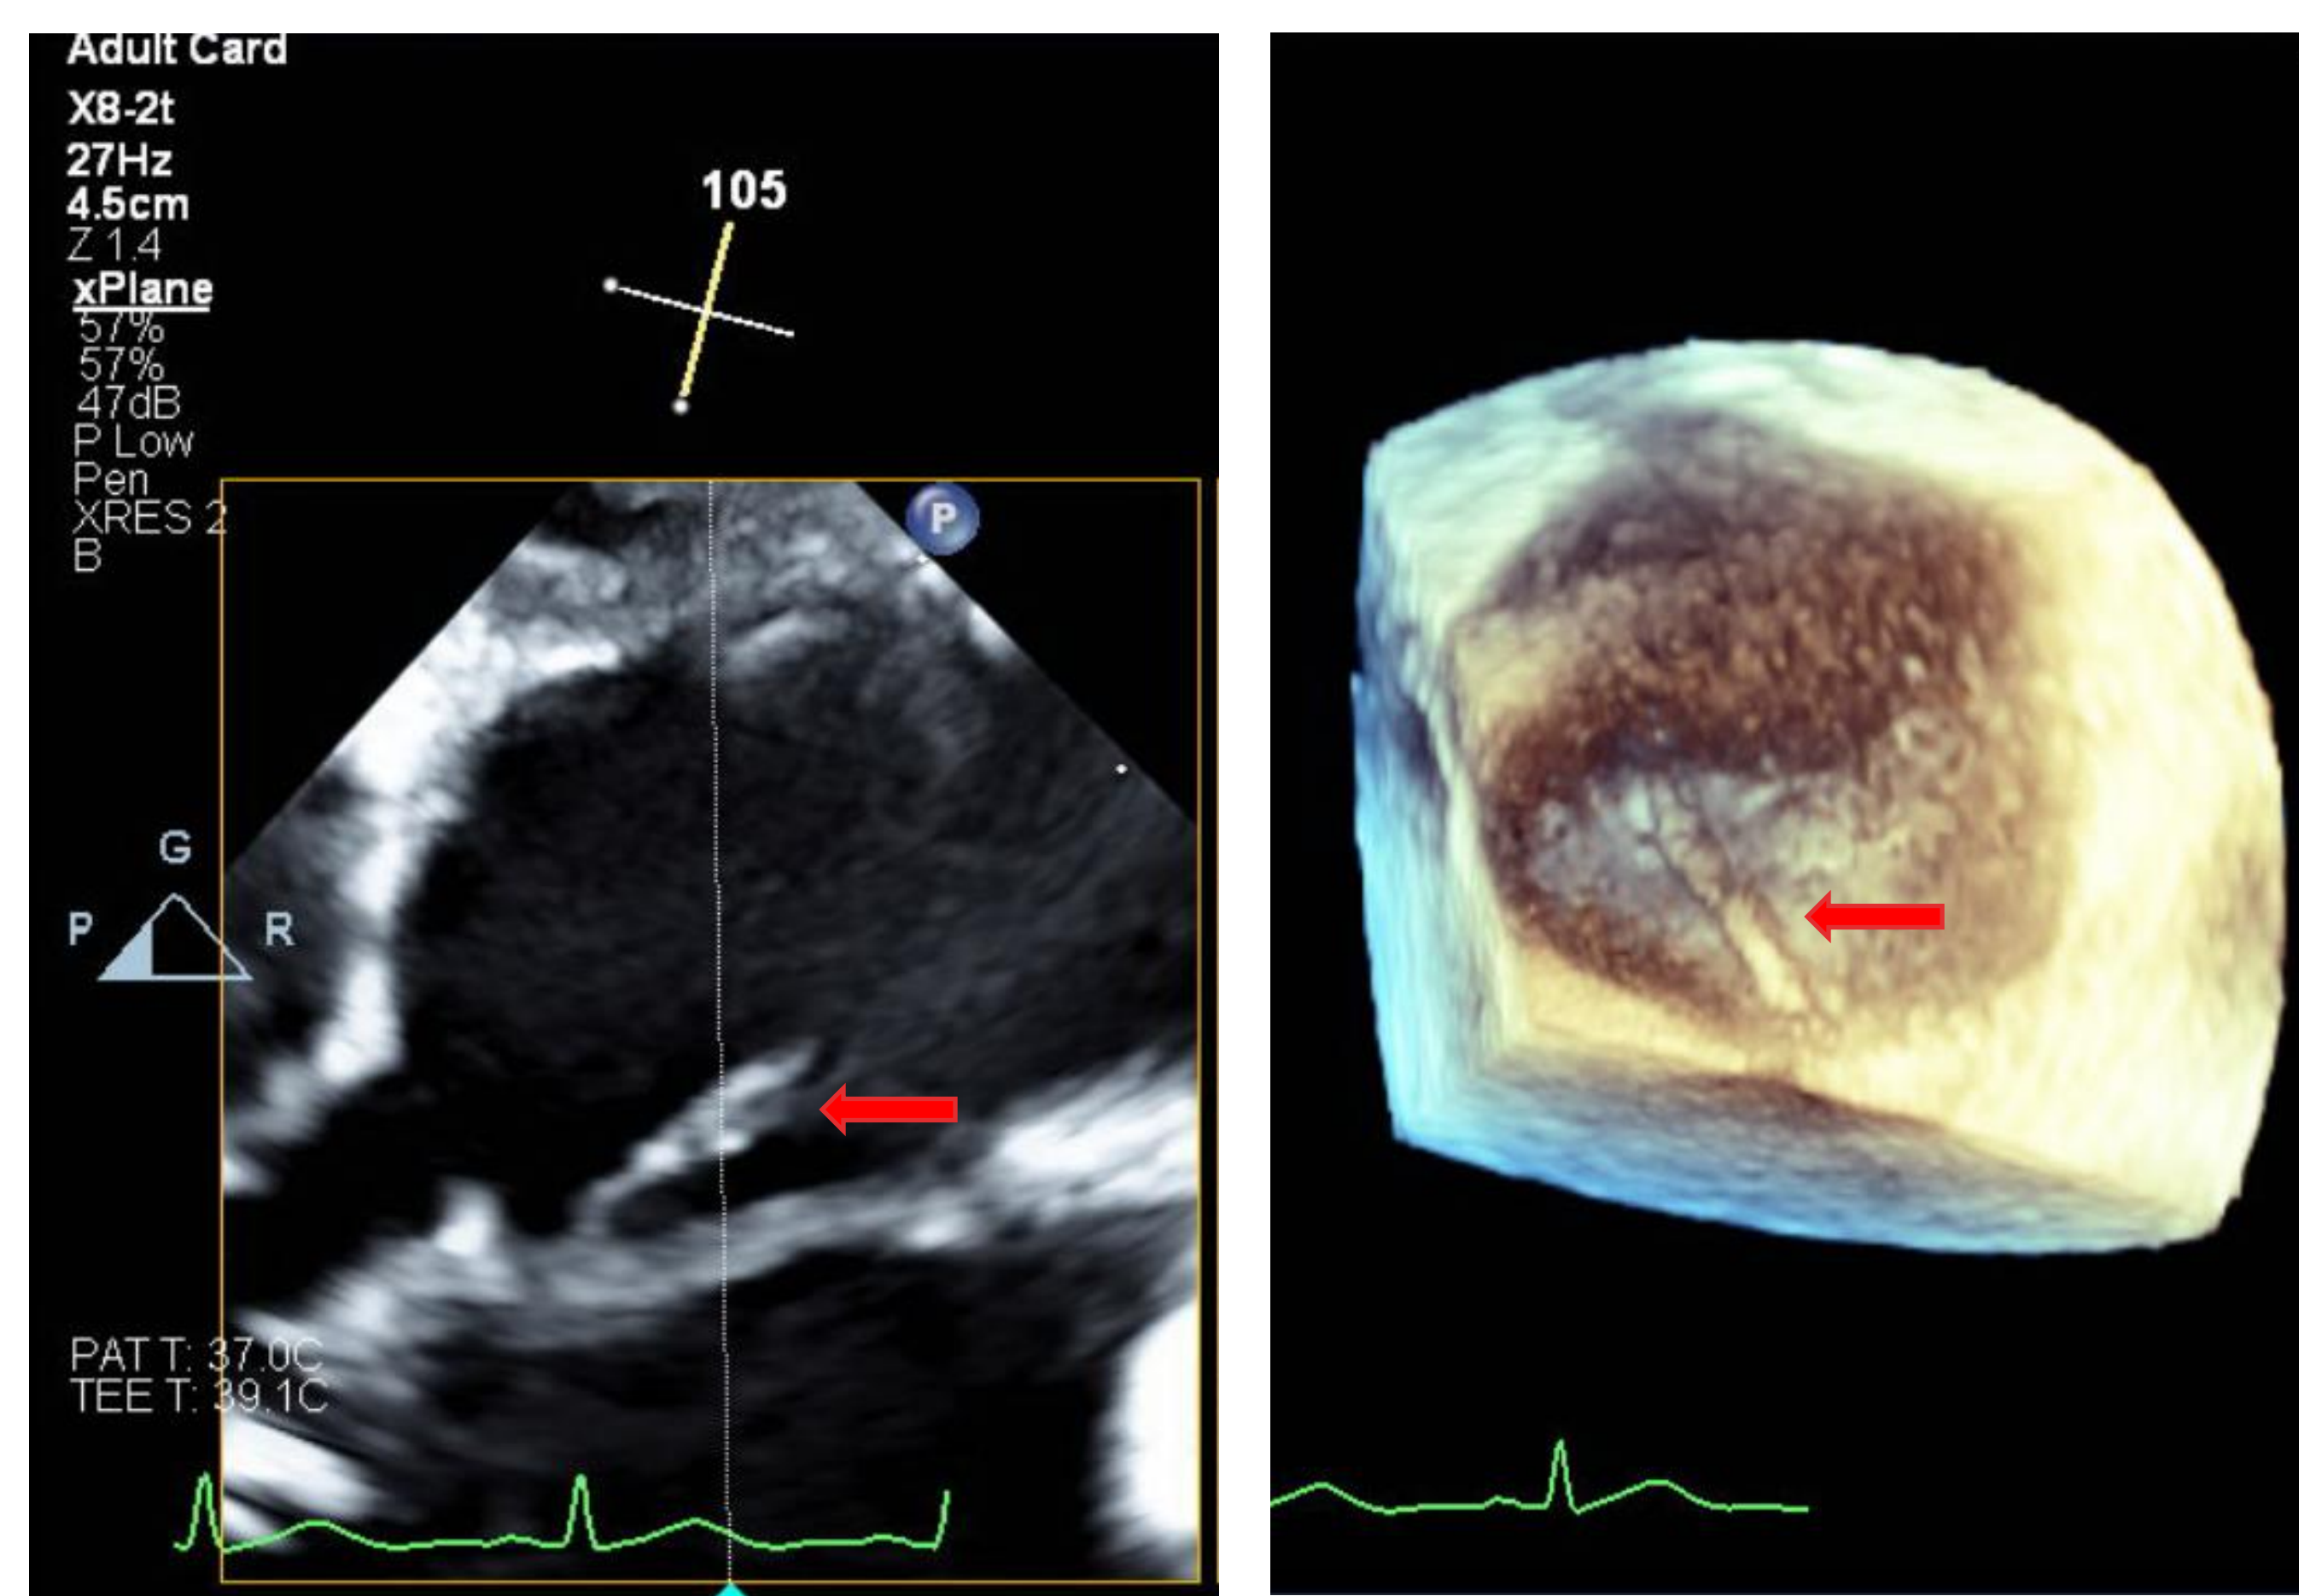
Transesophageal echocardiogram demonstrating vegetation attached to the mitral valve
